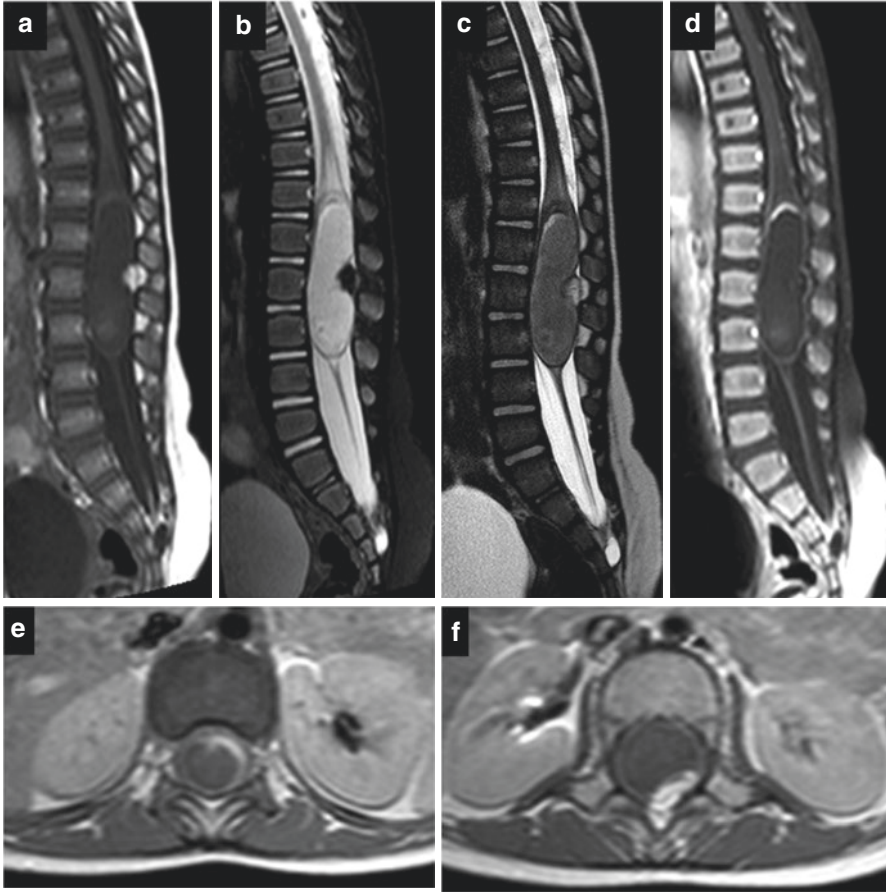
MR appearance of intra-medullary abscess in occult spinal dysraphism. Sagittal T1-weighted (a), T2w fat suppressed (b), B-FFE (c) and GD-enhanced fat suppressed T1-weighted (d) images; axial GD-enhanced T1-weighted images at D12 (e) and L2 (f) levels. MRI shows massive expansion of the medullary conus by fluid collection in patient affected by tethered cord with intradural lipoma. Inhomogeneous signal of the fluid collection with sediment, marginal septa and contrast enhancement at the upper pole is shown. Note the subsequent edema in the adjacent spinal cord
